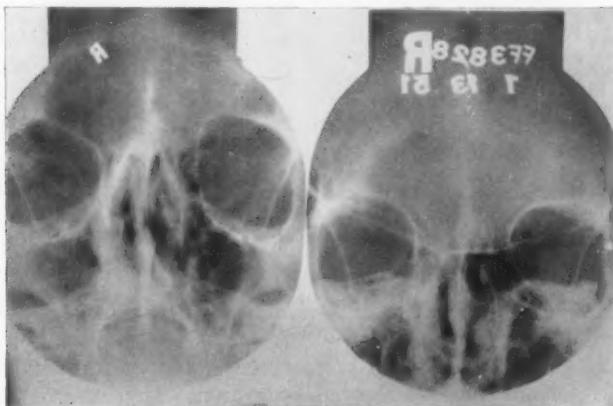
Roentgenogram showing increased density of right antrum, right ethmoid and both frontal sinuses and in addition the floor of the right frontal thinned out and depressed toward the orbit from an expanding fluid mass within the sinus—a finding characteristic of mucocele.
